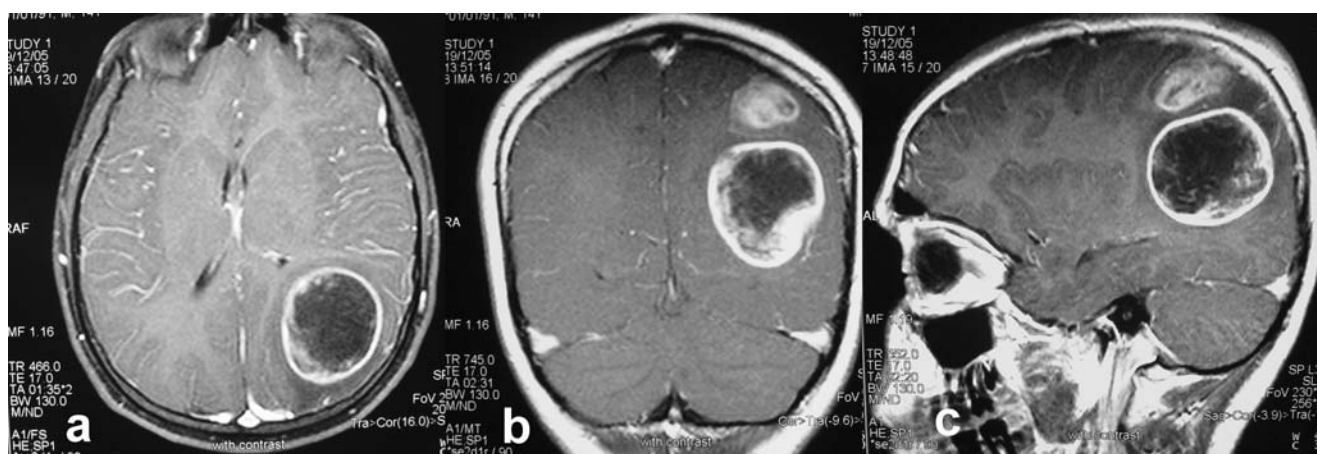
T1-weighted contrast-enhanced MRI scans a axial, b coronal, and c sagittal sections clearly reveals rapid progression
